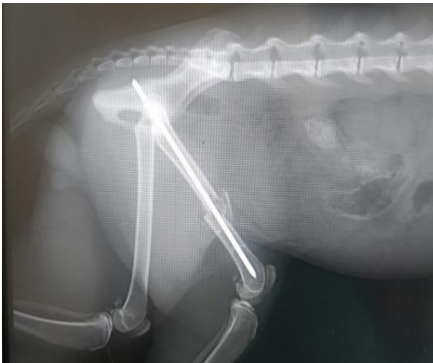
X-ray (after surgery)
